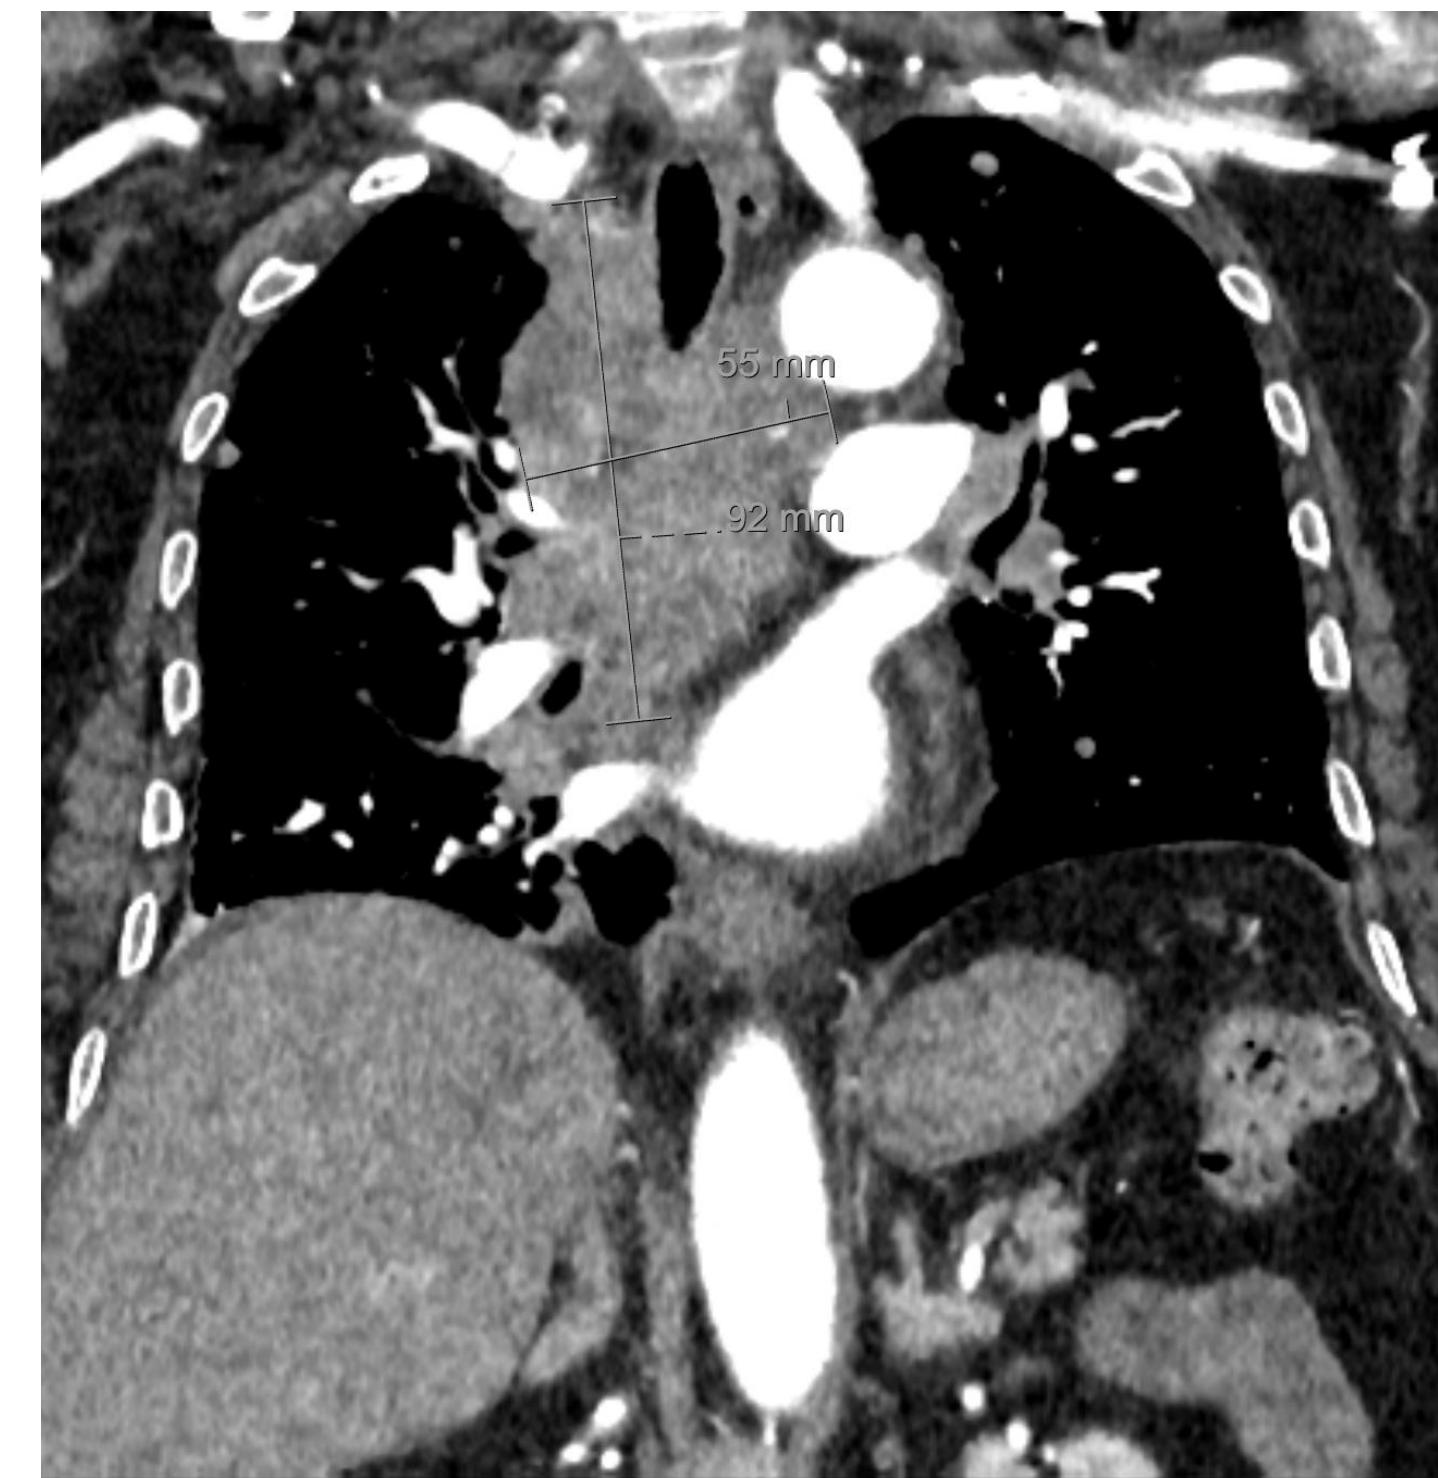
CT of the chest with contrast on coronal section shows a large conglomerate mediastinal adenopathy measuring 5.5 x 4.0 x 9.2 cm encasing the trachea and esophagus
